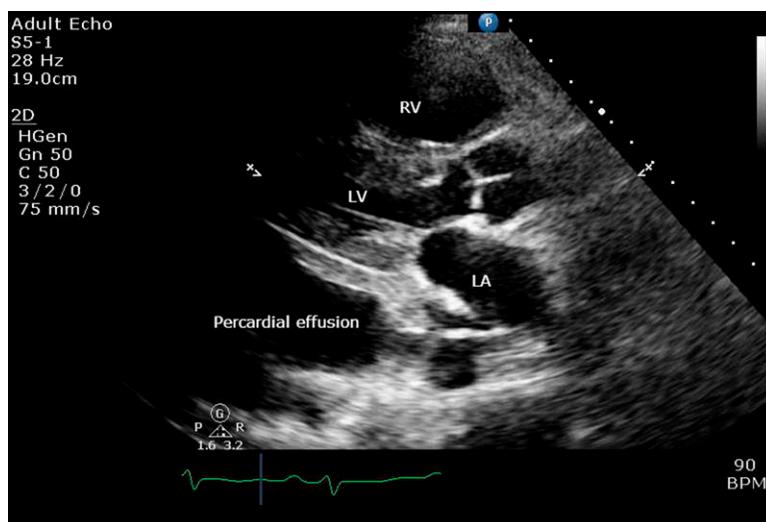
Parasternal long-axis view of the left atrium, left ventricle, and right ventricular outflow tract during ventricular systole. A large pericardial effusion is seen. BPM = beats per minute; LA = left atrium; LV = left ventricle; RV = right ventricle.
